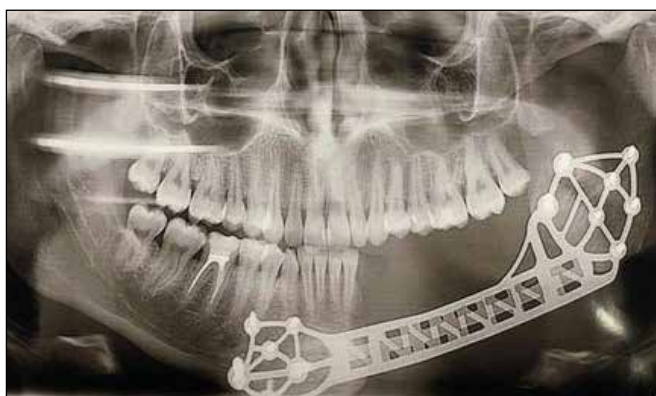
Control orthopantomogram of patient U., 23 years old, medical history № 4..5913.
